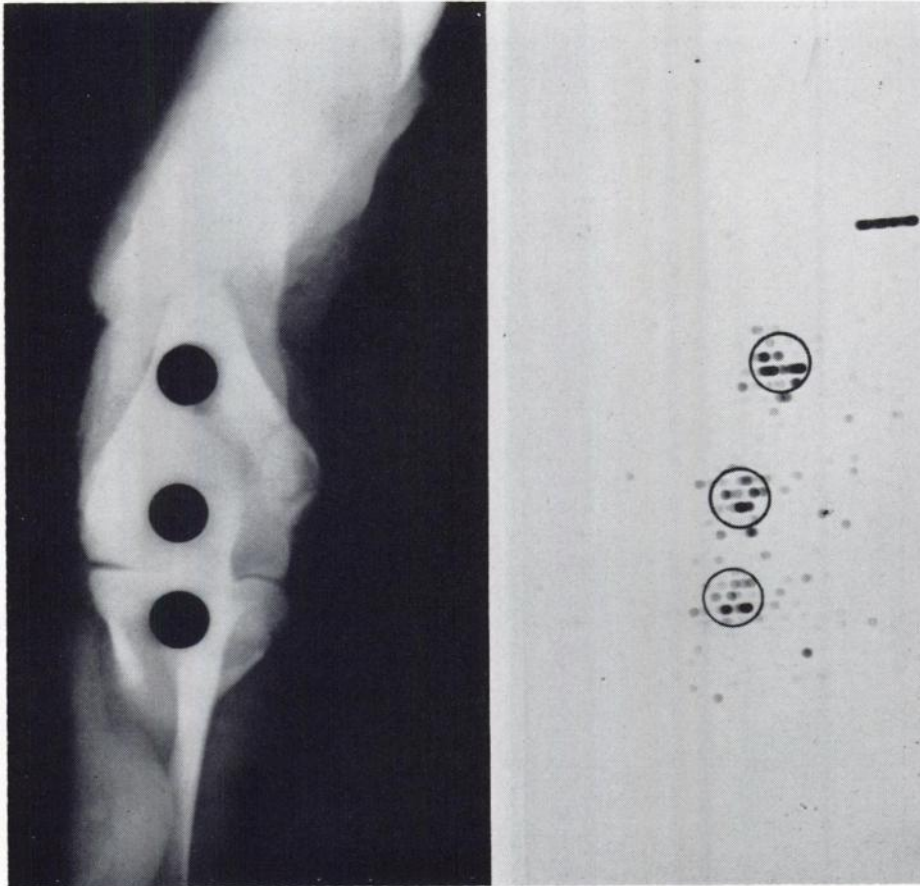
Roentgenogram (left) of veal leg containing $\frac{3}{8}$ " holes, in which test tubes of Sr^{85} solutions have been placed. (Right). Photoscan of preparation superimposed on test tube outline. Sr^{85} solutions contain (top to bottom): $0.20 \mu\text{c}$ in 5 ml; $0.16 \mu\text{c}$ in 4 ml; and $0.12 \mu\text{c}$ in 3 ml.
